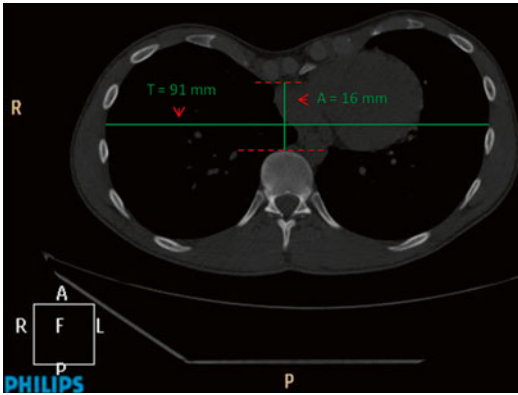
CT axial image: Calculation of the *Haller Index* = 91 mm/16 mm = 5.68. The sternum is so severely depressed that it is 1.6 cm from the anterior portion of the vertebra
